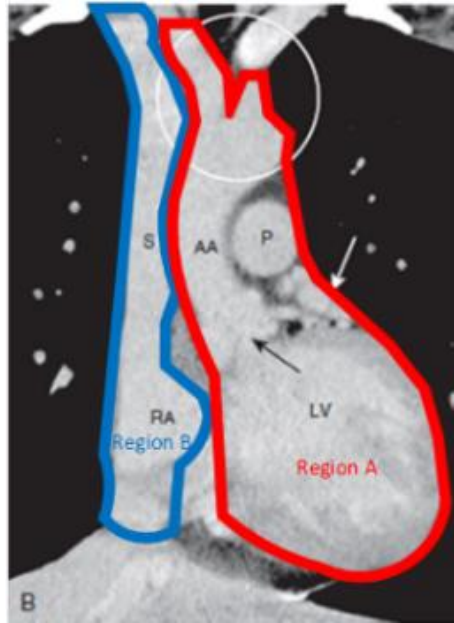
CT scan of the heart region. [5]
